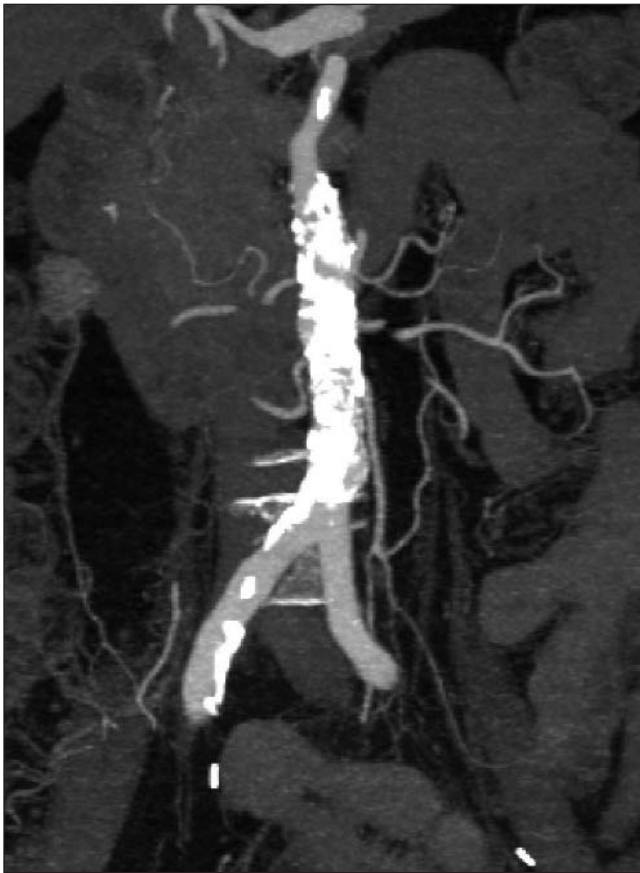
Preoperative computed tomography angiography demonstrating severe calcific stenosis of the distal aorta
